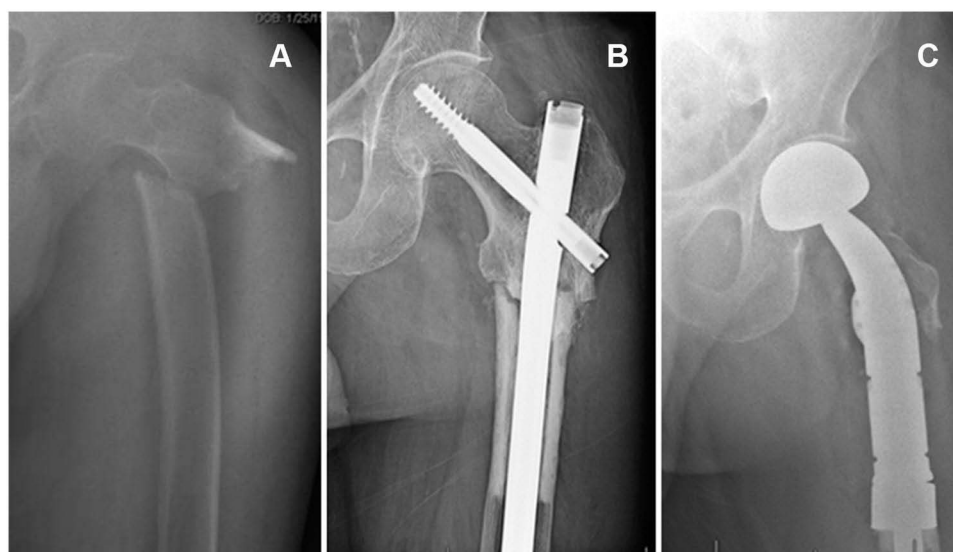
(A) Plain radiograph showing pathological fracture of proximal femur after radiation. (B) Initial stabilization of fracture with IM nail. (C) Fracture nonunion lead to final management with proximal femur resection and reconstruction with megaprosthesis.
